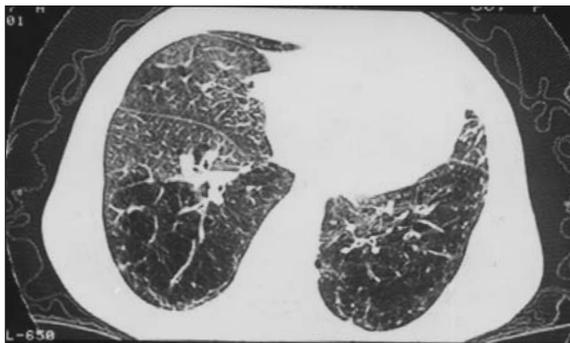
HRCT scans taken at right middle lobe level at end-expiration showed exaggeration of heterogeneity of lung density consistent with air trapping.
